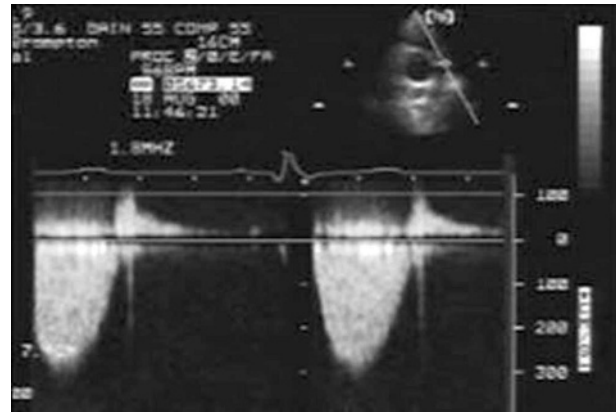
Continuous wave Doppler tracing of the RVOT in a patient with combined pulmonary valve stenosis and regurgitation. Note that the signal of pulmonary regurgitation (above the zero line) ends well before the next systolic Doppler wave (below the line). This may be either due to severe pulmonary regurgitation, or to elevated RV diastolic pressure.
